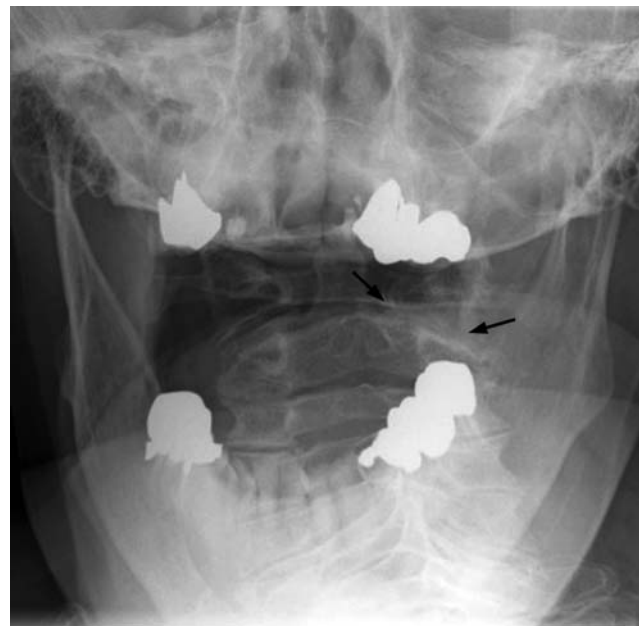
Open-mouth odontoid radiograph showing bilateral C1-C2 joints with unilateral arthritic changes (arrows).
